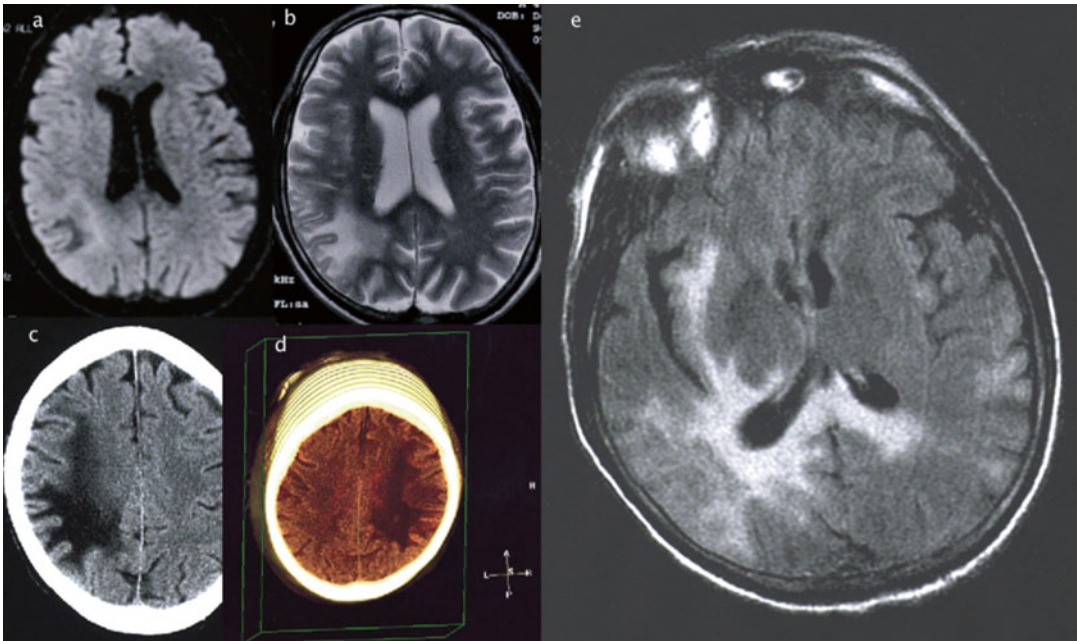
Case example: HIV-related PML as shown by MRI (a, b) and CT (c, d) at the time of diagnosis when the patient presented with seizure activity and progressive
